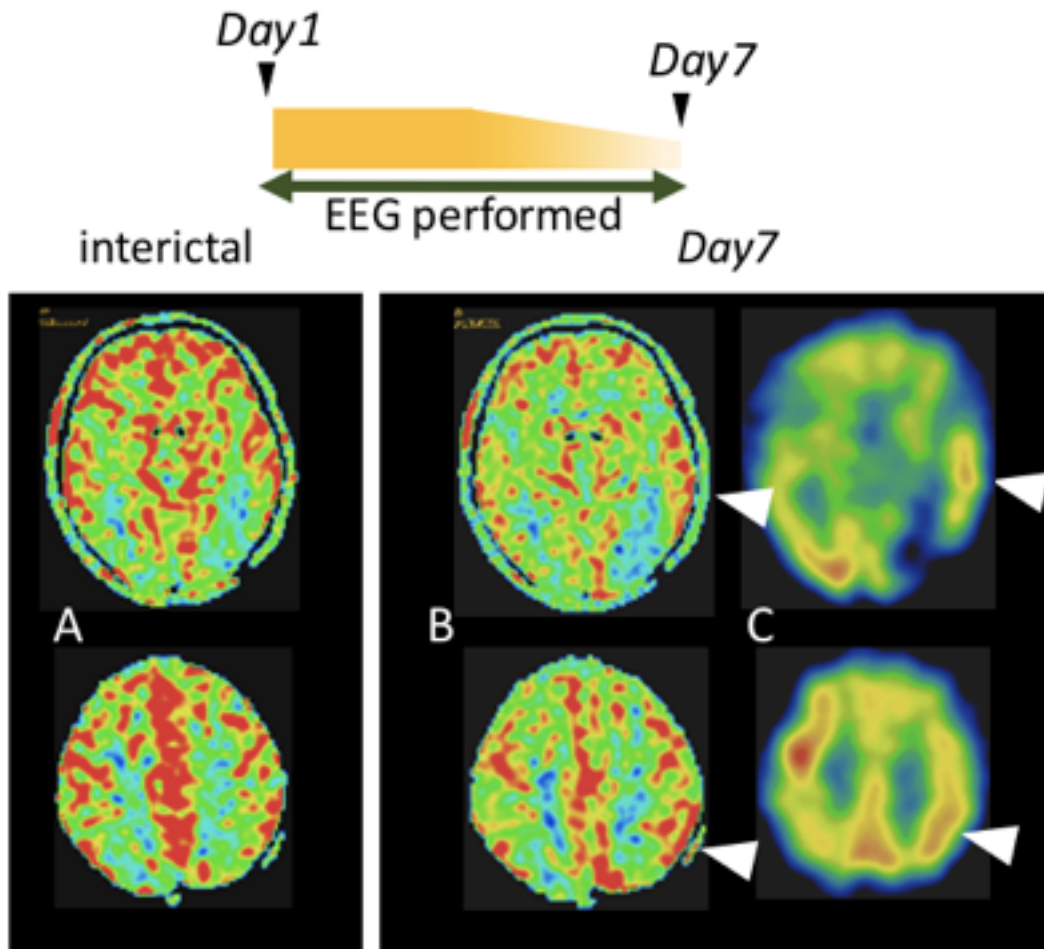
Periictal PASL-MRI (B) and IMP-SPECT (C) on Day 7 in the second SPSE, when left periodic discharges on EEG continued. (A) Interictal PASL-MRI. (B and C) Hyperperfusion at left temporal and parietal lobes was seen on both modalities. (arrowheads)
